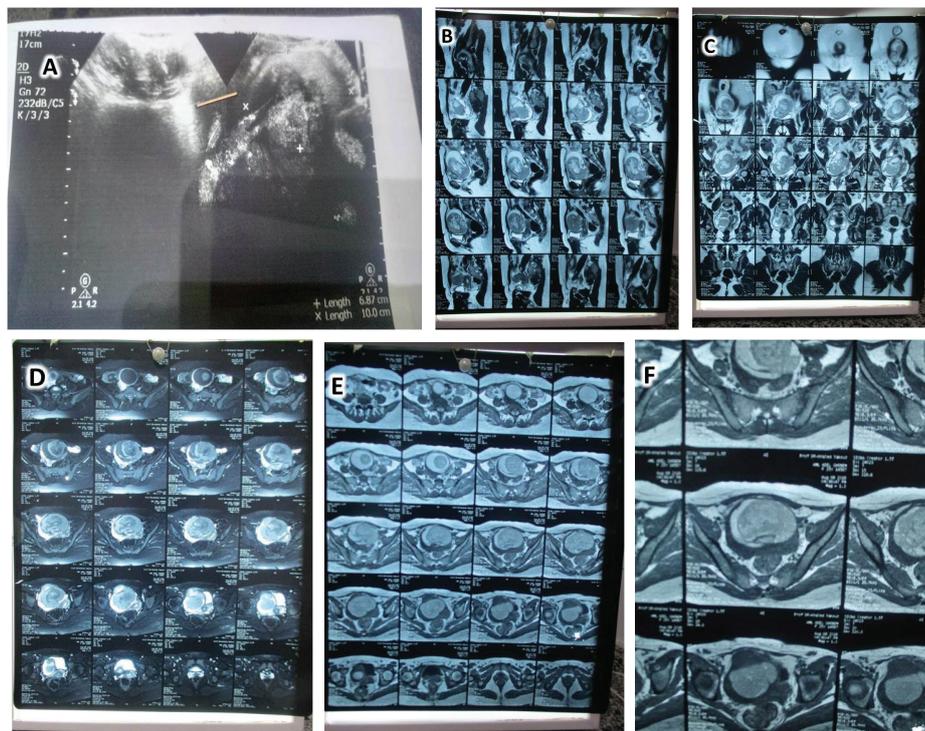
Radiological features. (A) Ultrasound abdomen showed a massive solid and cystic mass arising from the right adnexa. B-F MRI pelvis showed a large teratodermoid cyst, pelvic lymph nodes enlargement, and omental deposits.
